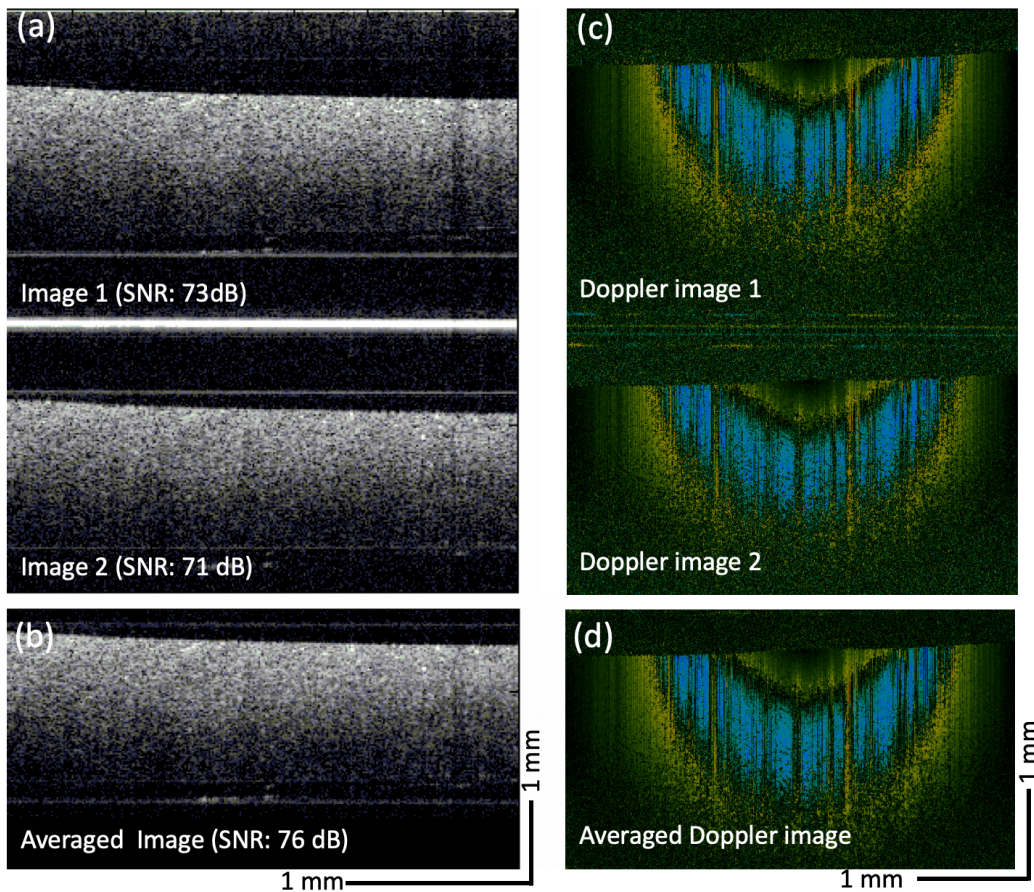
SNR quantification. (a) and (b): Original and averaged OCT images, respectively. (c) and (d): Original and averaged Doppler OCT images, respectively.
